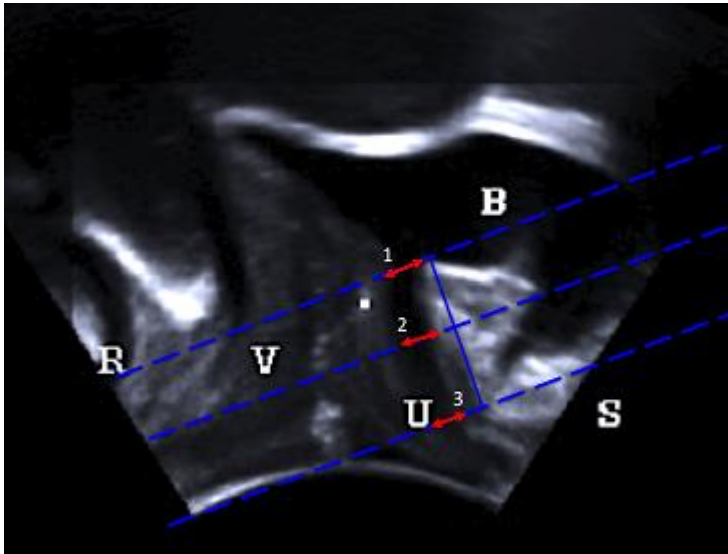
Perineal ultrasound presentation of the urethral lumen U1 (1), urethral lumen U2 (2), urethral lumen U3 (3), bladder (B), the symphysis (S), urethra (U), vagina (V), rectum (R).
